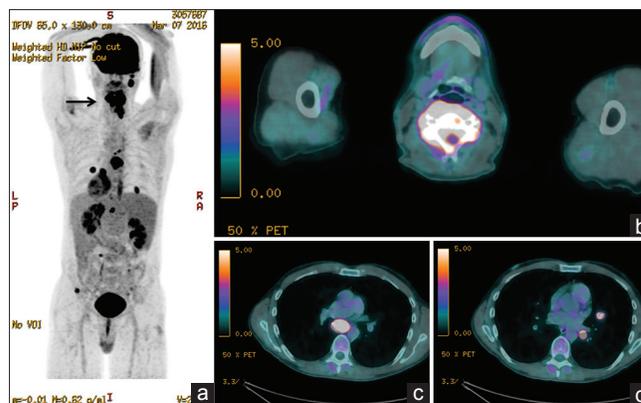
18F fluorodeoxyglucose-positron emission tomography showing a highly hypermetabolic nature of the cervical vertebral mass (SUVbw maximum: 17.9 g/ml) (arrow in a and b) associated with a hypermetabolic infracardinal ganglion (SUVbw maximum: 14.3 g/ml) (c) and multiple hypermetabolic pulmonary nodules (SUVbw maximum: 15.6 g/ml) (d)
